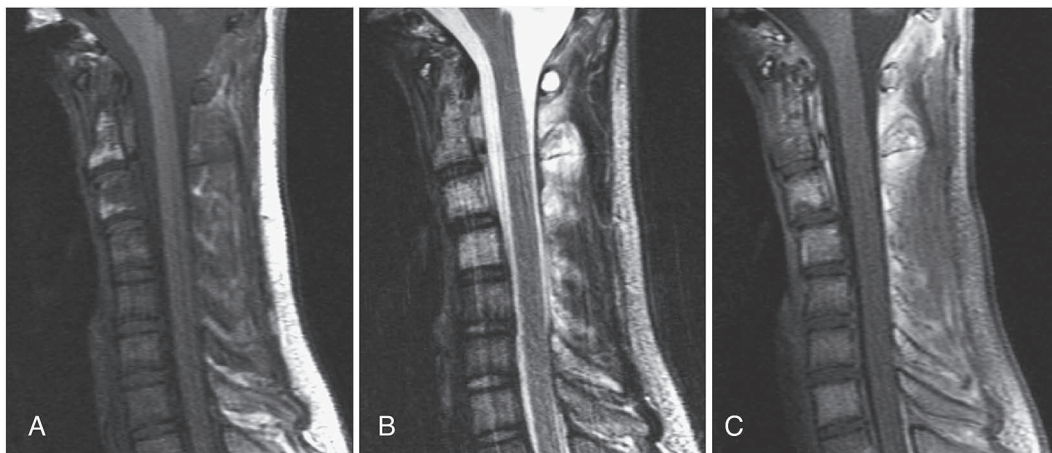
Magnetic resonance imaging (MRI) of the cervical spine on admission. The vertebral bodies, laminae, and spinous processes from C1 to C5 showed a low signal intensity on T1-weighted images and a heterogeneously high signal intensity on T2-weighted images (A, B). They were slightly enhanced by Gd-DTPA (C).
